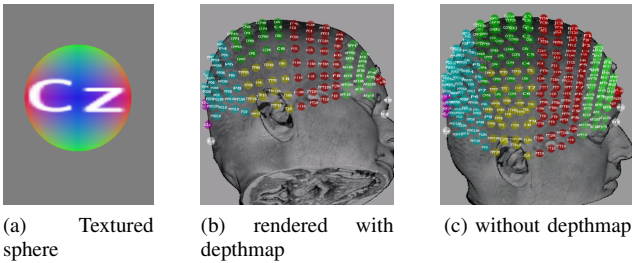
Multimodal rendering of EEG and MRI.
